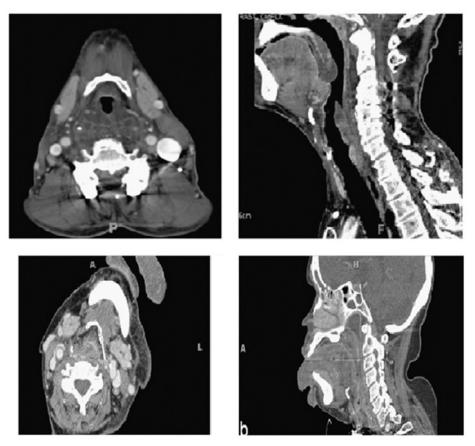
Medication-induced angioedema of the upper airway seen in two patients. Diffuse mucosal and submucosal edema is seen in these contrast-enhanced axial and sagittal CT images through the upper airway. Mild narrowing of the airway is seen in the first patient (top left and right), and complete occlusion of the airway is seen in the second patient (bottom left and right).
